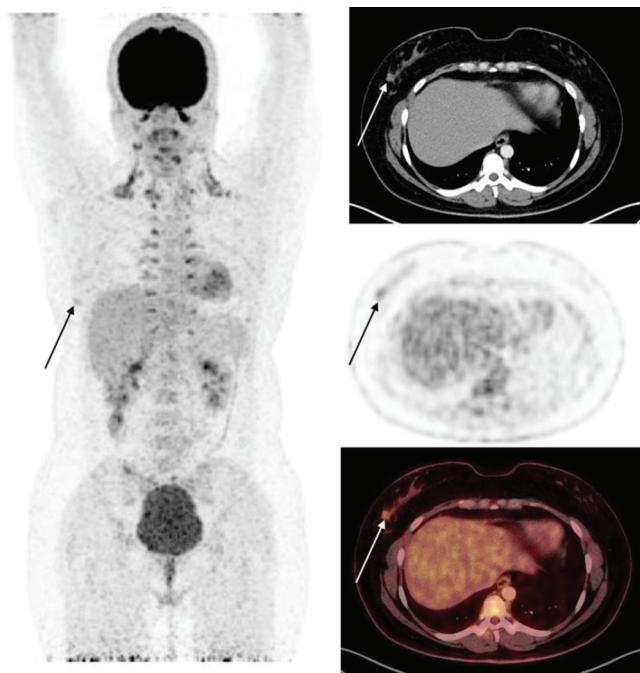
Twenty-seven-year-old-female, stage IIA 80% micropapillary component, 20% invasive ductal component breast cancer patient. Mildly hypermetabolic lesion located in the right breast was shown (SUV_{max} : 2.1 mg/dL; arrow)
